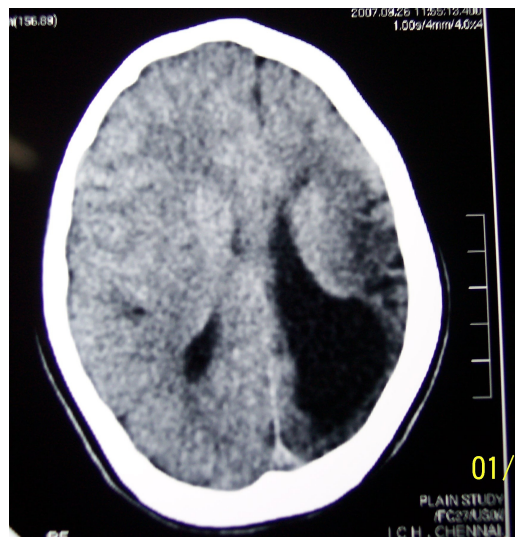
CT picture showing porencephalic cyst left communicating with lateral ventricle with cerebral atrophy of left hemisphere.
